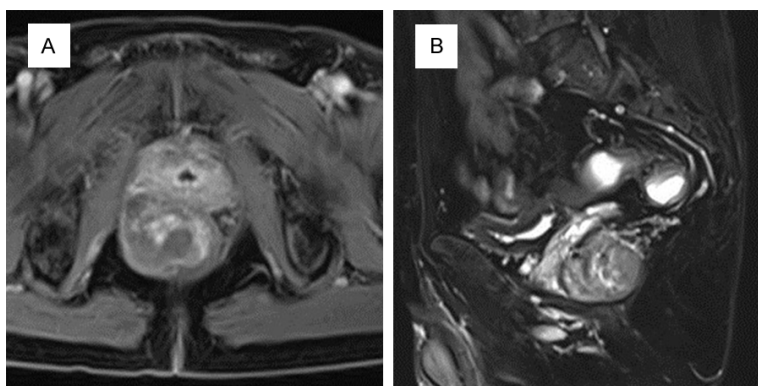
(A) Transverse and (B) sagittal sections of pelvis MRI imaging after 2 months of imatinib treatment. A significant reduction in the size of the rectal mass was shown.
